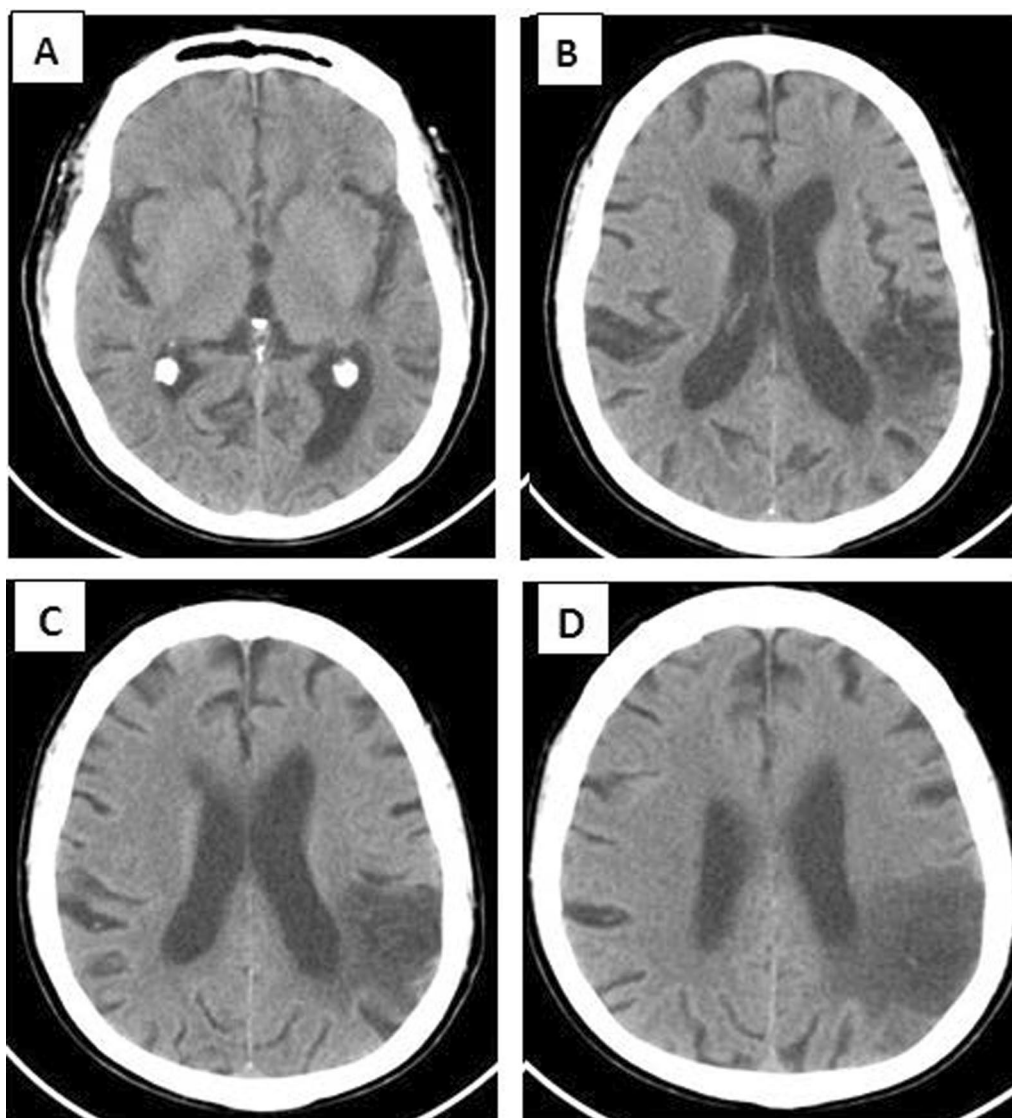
A–D Sequential axial non-contrast CT images of the brain reveal a hypodense area of infarction at the left temporoparietal region (M5 and M6 regions); ASPECTS = 8
